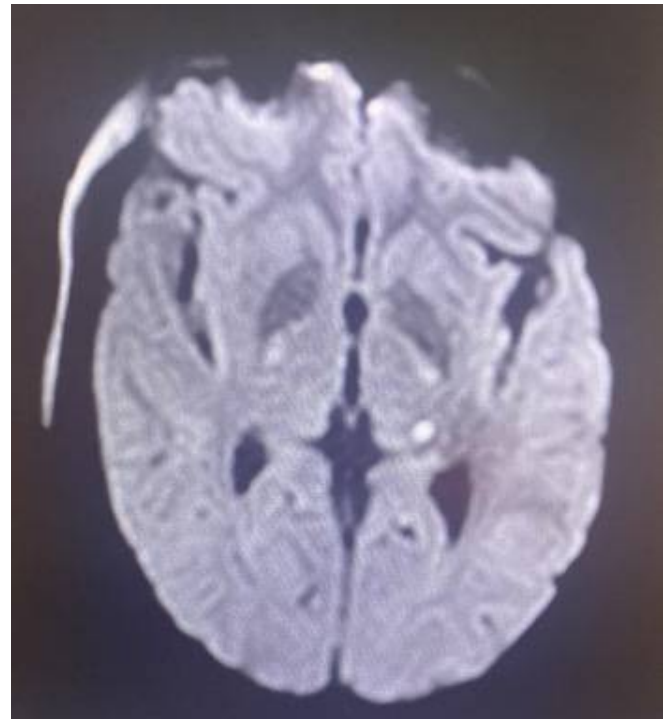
Axial DWI image shows diffusion restriction at posterolateral aspect of left thalamus s/o infarct.
